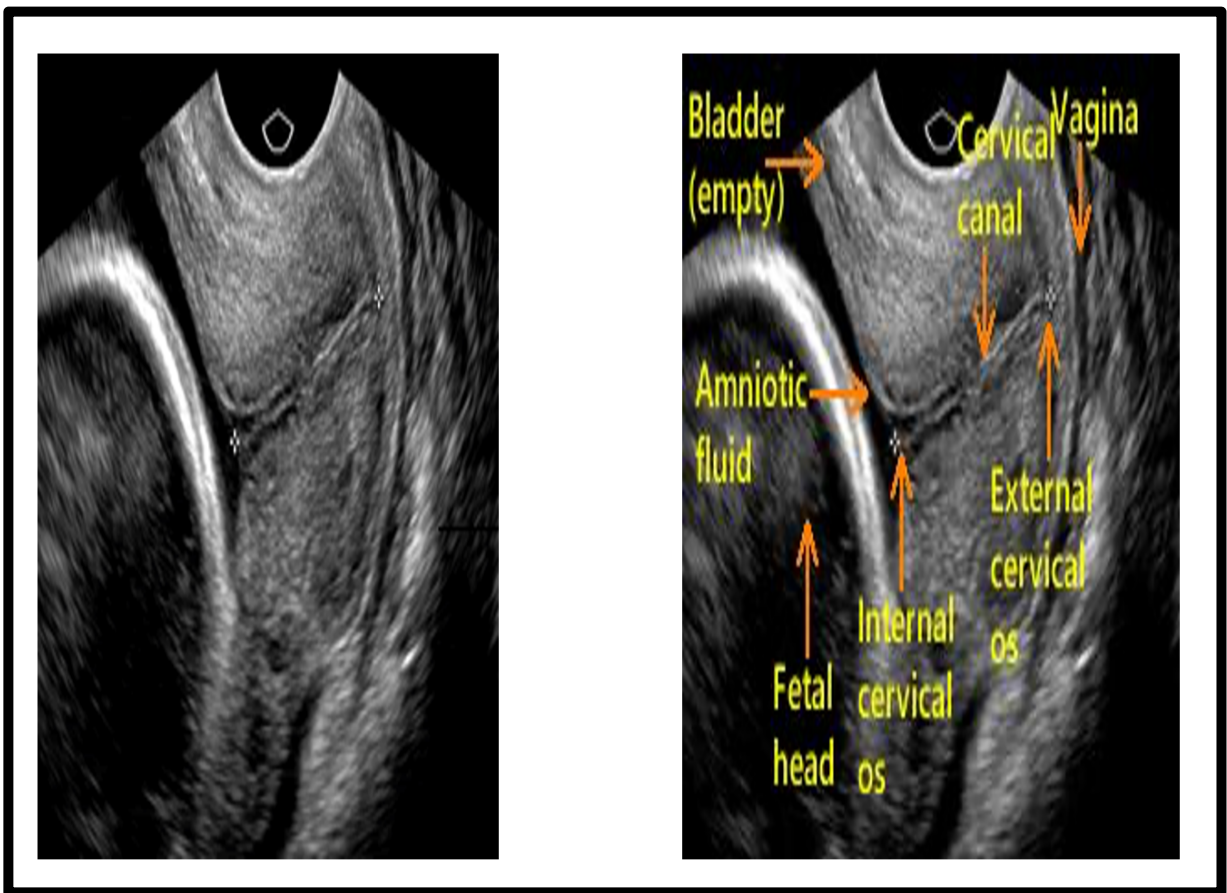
Normal Transvaginal ultrasound image showing the cervix in the sagittal view (credit: obimages.net)
